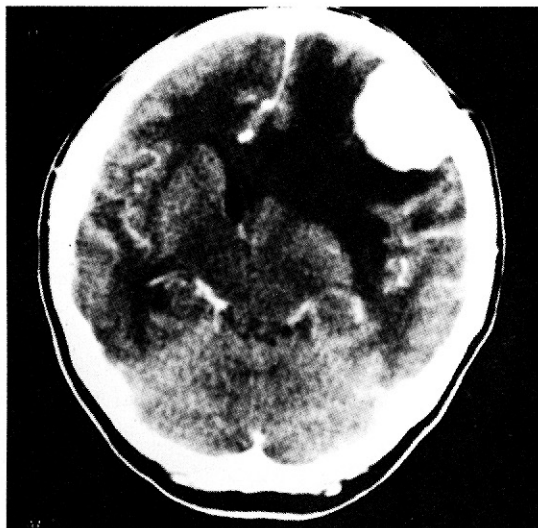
Brain CT scan. A well-circumscribed mass is present in the left frontal lobe and is attached to the inner table of the skull. Marked edema of surrounding cerebral tissue is associated.
